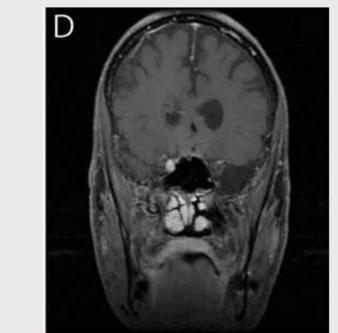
Pre-operative MRI with contrast
